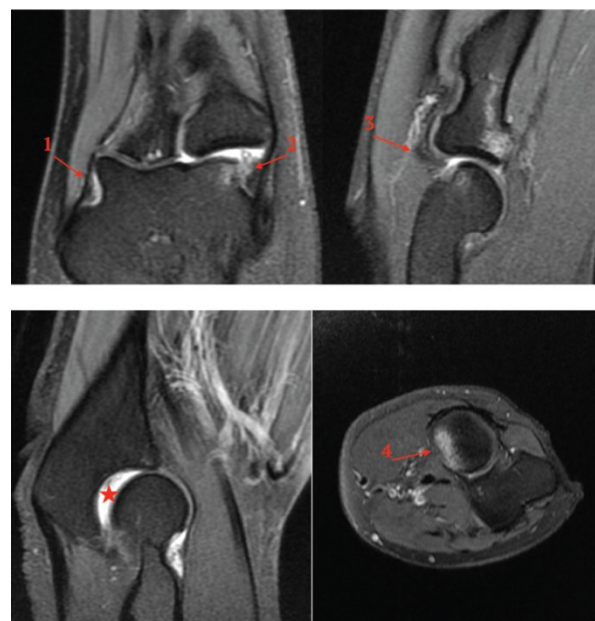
Magnetic resonance imaging of the right elbow joint of a 38-year-old patient. 1 – damage to the medial collateral ligament; 2 – damage to the lateral ligamentous complex and the common extensor tendon of the wrist and hand; 3 – damage to the lateral ligamentous complex and the posterolateral part of the capsule of the elbow joint; 4 – damage to the annular ligament. * – subluxation of the ulna
